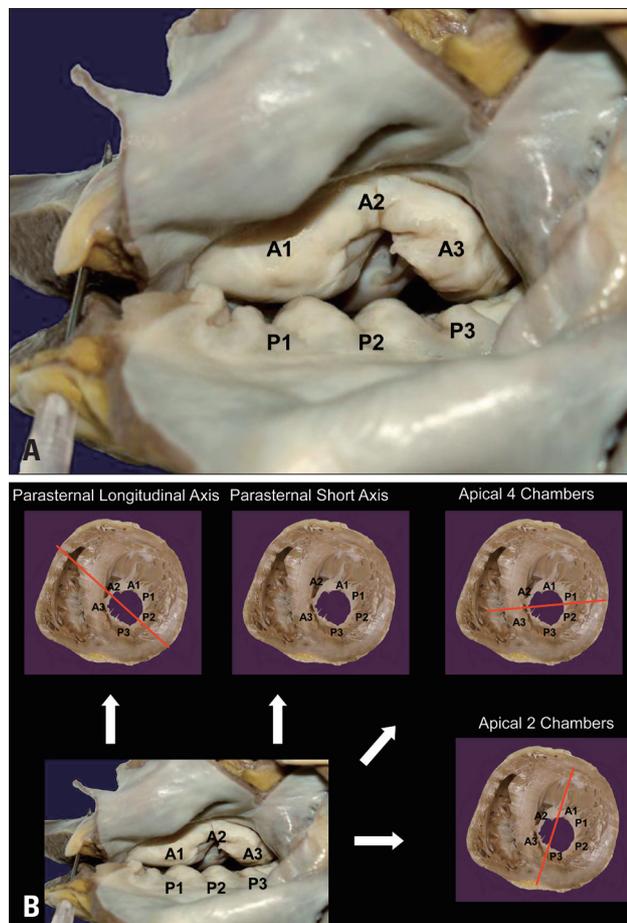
Surgical view of the mitral valve (A). Spatial orientation of the most commonly used two-dimensional transthoracic echocardiographic views (B). Leaflet segmentation starts with A1-P1 close to the anterolateral commissure, A2-P2 centrally, and A3-P3 close to the posteromedial commissure.
